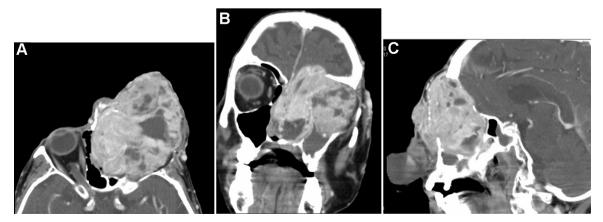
Axial (A), coronal (B), and sagittal (C) views of the computed tomography showing a giant ill-demarcated left orbital mass, that presented both intracranial and sinonasal invasion with bony destruction.
